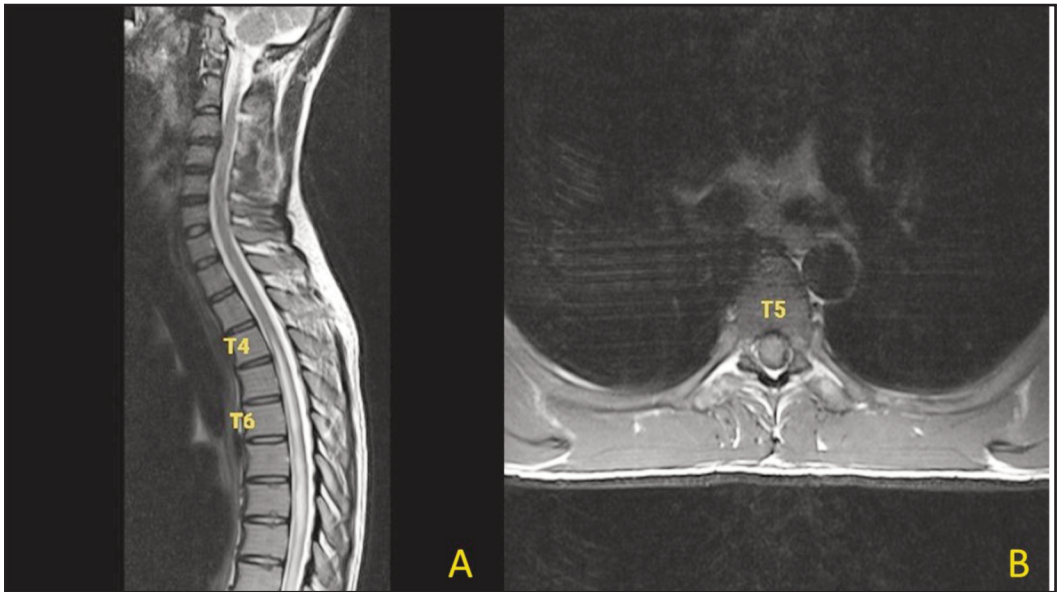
T2-weighted Magnetic Resonance Image. (A) Sagittal view shows intramedullary enhancement of patchy T2 hyperintense lesion with contrast enhancement at T4 to T6 level (B) Axial view shows central intramedullary contrast-enhanced lesion at T5 level.
